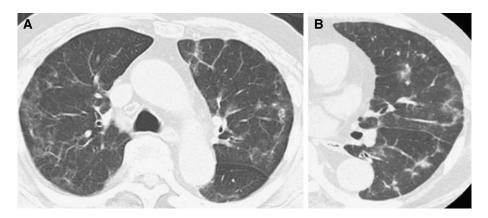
Drug-induced lung injury, nonspecific interstitial pneumonia (NSIP)-like pattern. Bucillamine-induced lung injury (NSIP-like pattern) in a 74-yearold man with dyspnea who had been treated with bucillamine for 2 months. (A) Computed tomography (CT) and (B) high-resolution CT, showing multiple foci of ground-glass opacity along the bronchovascular bundles that mimic NSIP.
